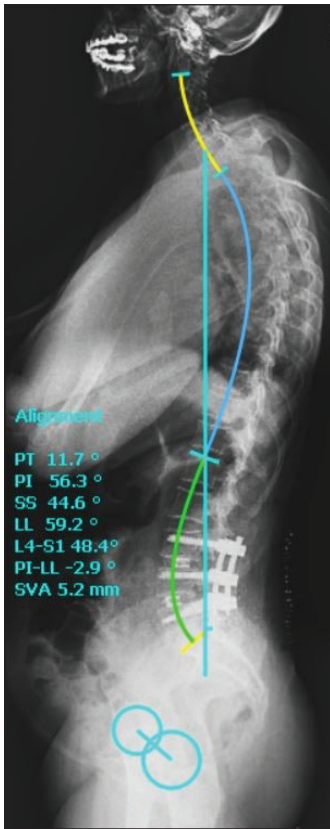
Postoperative lateral X-ray of the patient who underwent short-level fusion.
